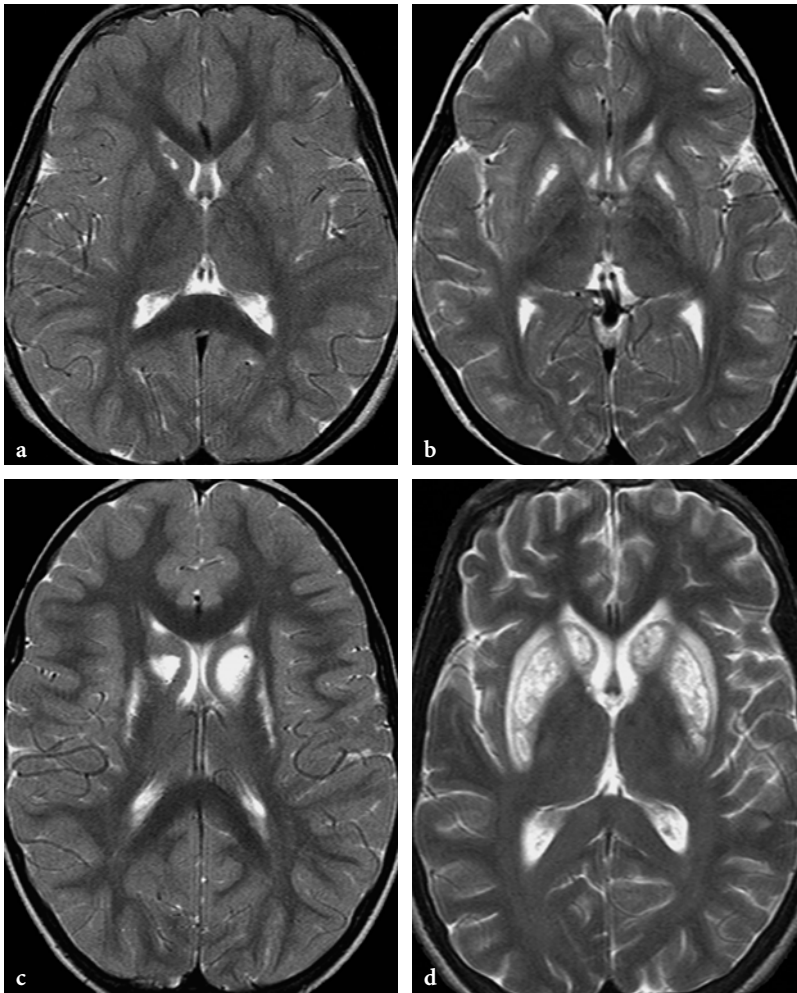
The MRI appearance of basal ganglia lesions in biotin-responsive basal ganglia disease on axial T2-weighted fast spin-echo images. a 3-year-old female patient. Very subtle signal changes are seen within the head of the right caudate nucleus and within the left putamen anteriorly. b 4-year-old female patient. More prominent and symmetrical lesions within putamina and caudate nuclei. c 5-year-old female patient. More extensive involvement of basal ganglia with marked swelling of the heads of caudate nuclei. d 16-year-old female patient. Very marked signal changes and swelling of the basal ganglia, also involving the adjacent external capsules
